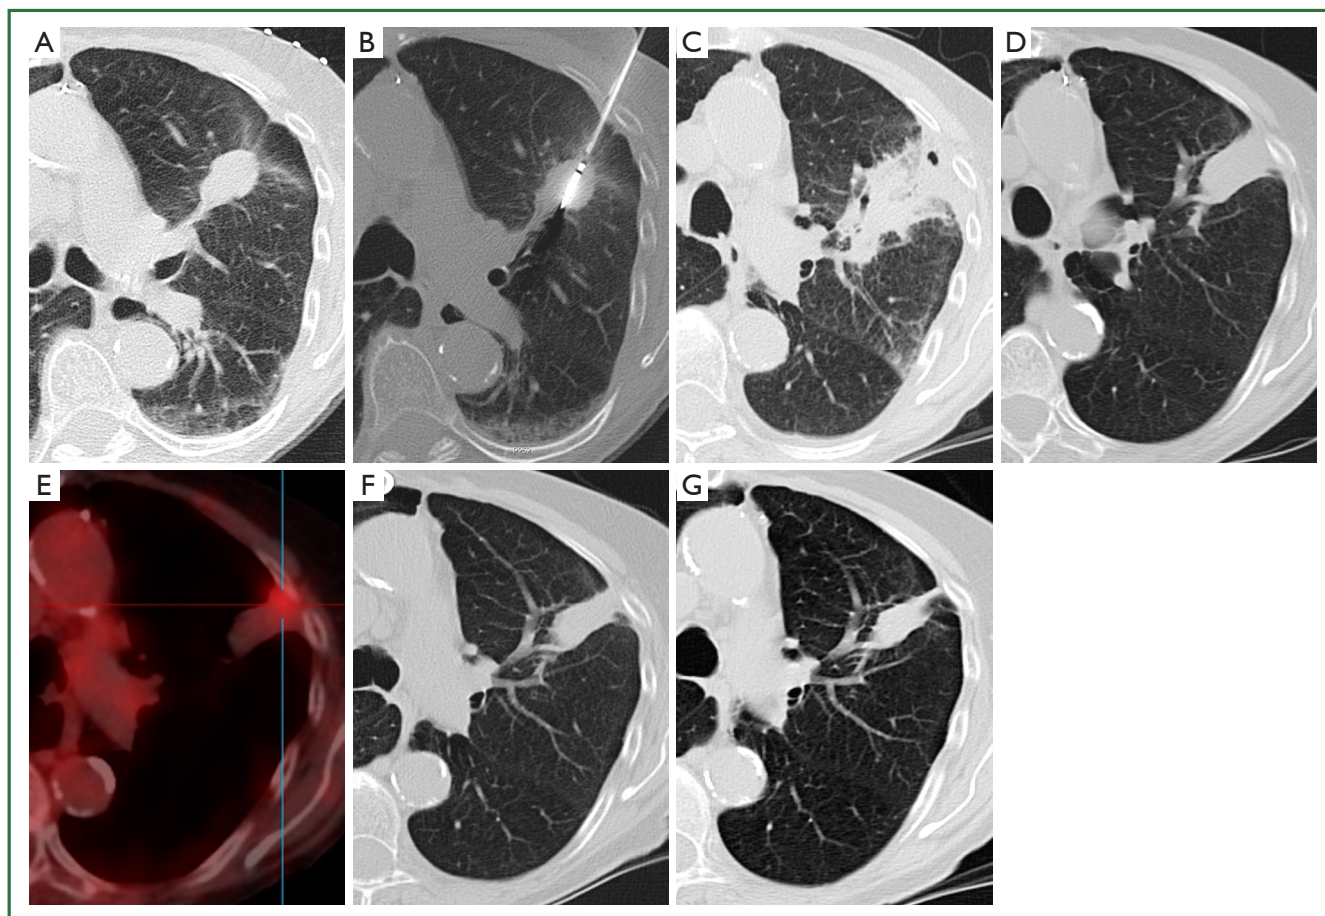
A 75-year-old ex-smoker with prior RFA of biopsy-proven left upper lobe NSCLC. FDG-PET 3 months following RFA was equivocal for residual tumour and repeat treatment with CT-guided MWA was performed. A. Axial CT image shows a 3 cm left upper lobe mass; B. Axial CT shows microwave antenna is positioned within the centre of the mass; C. Axial CT 24 hours following MWA shows ablation site encompasses target lesion. There is a focal pleural effusion with small cavity, and surrounding atelectasis and ground glass opacity changes; D, E. Axial CT (D) and axial fused FDG-PET/CT (E) 6 months following ablation show resolution of the ground glass opacity and shrinking of the ablation volume, but a residual broad-based pleural contact remain. FDG-PET/CT shows lack of FDG-avidity of the ablated lesion but mild sub-pleural FDG uptake, likely inflammatory; F, G. Axial CT 12 months (F) and 24 months (G) following ablation show further gradual shrinking of the ablation volume and narrowing of the pleural contact.
